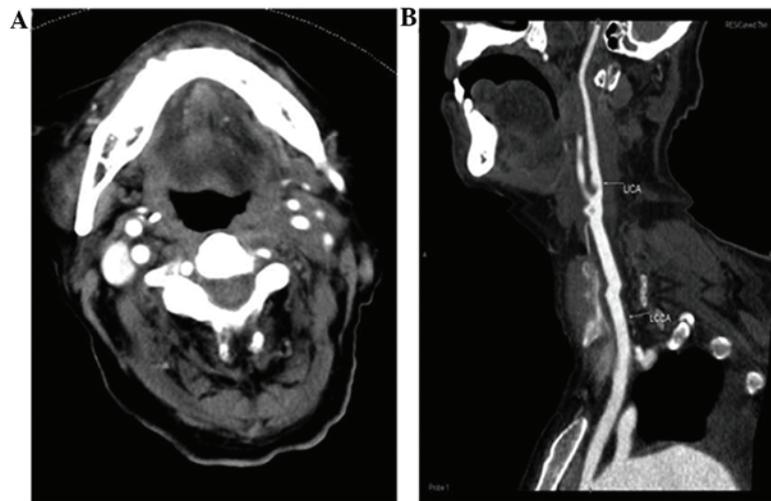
Computed tomography angiography scan of the head and neck following chemotherapy and radiotherapy. (A) The mass in the left submandibular area had almost disappeared; (B) the soft tissue mass at the level of the left carotid artery bifurcation and above had clearly decreased in size smaller compared with prior to treatment. The left common carotid artery bifurcation and internal and external carotid artery segments that were previously embedded in the mass were also clearly visualized.
